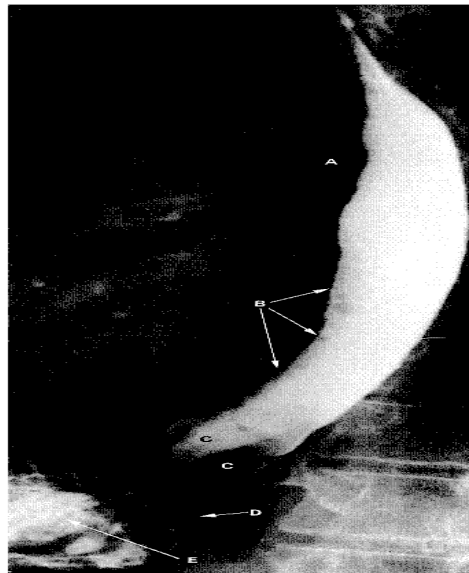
An oblique radiograph of the thorax during the esophageal transit of part of a 'meal' of barium sulphate paste. At [A] the translucency of the air-containing right principal bronchus is visible. The concave ventral aspect of the esophagus [B] is topographically related to the pericardium covering the left atrium of the heart. Longitudinal mucosal folds are visible [C] immediately proximal to the soft tissue shadow of the diaphragm [D]. Some barium sulphate is already admixed with the gastric contents [E]. The esophagus in the lower thorax curves ventrally away from the vertebral column to reach the esophageal orifice in the diaphragm (*Gray, 2000*).
